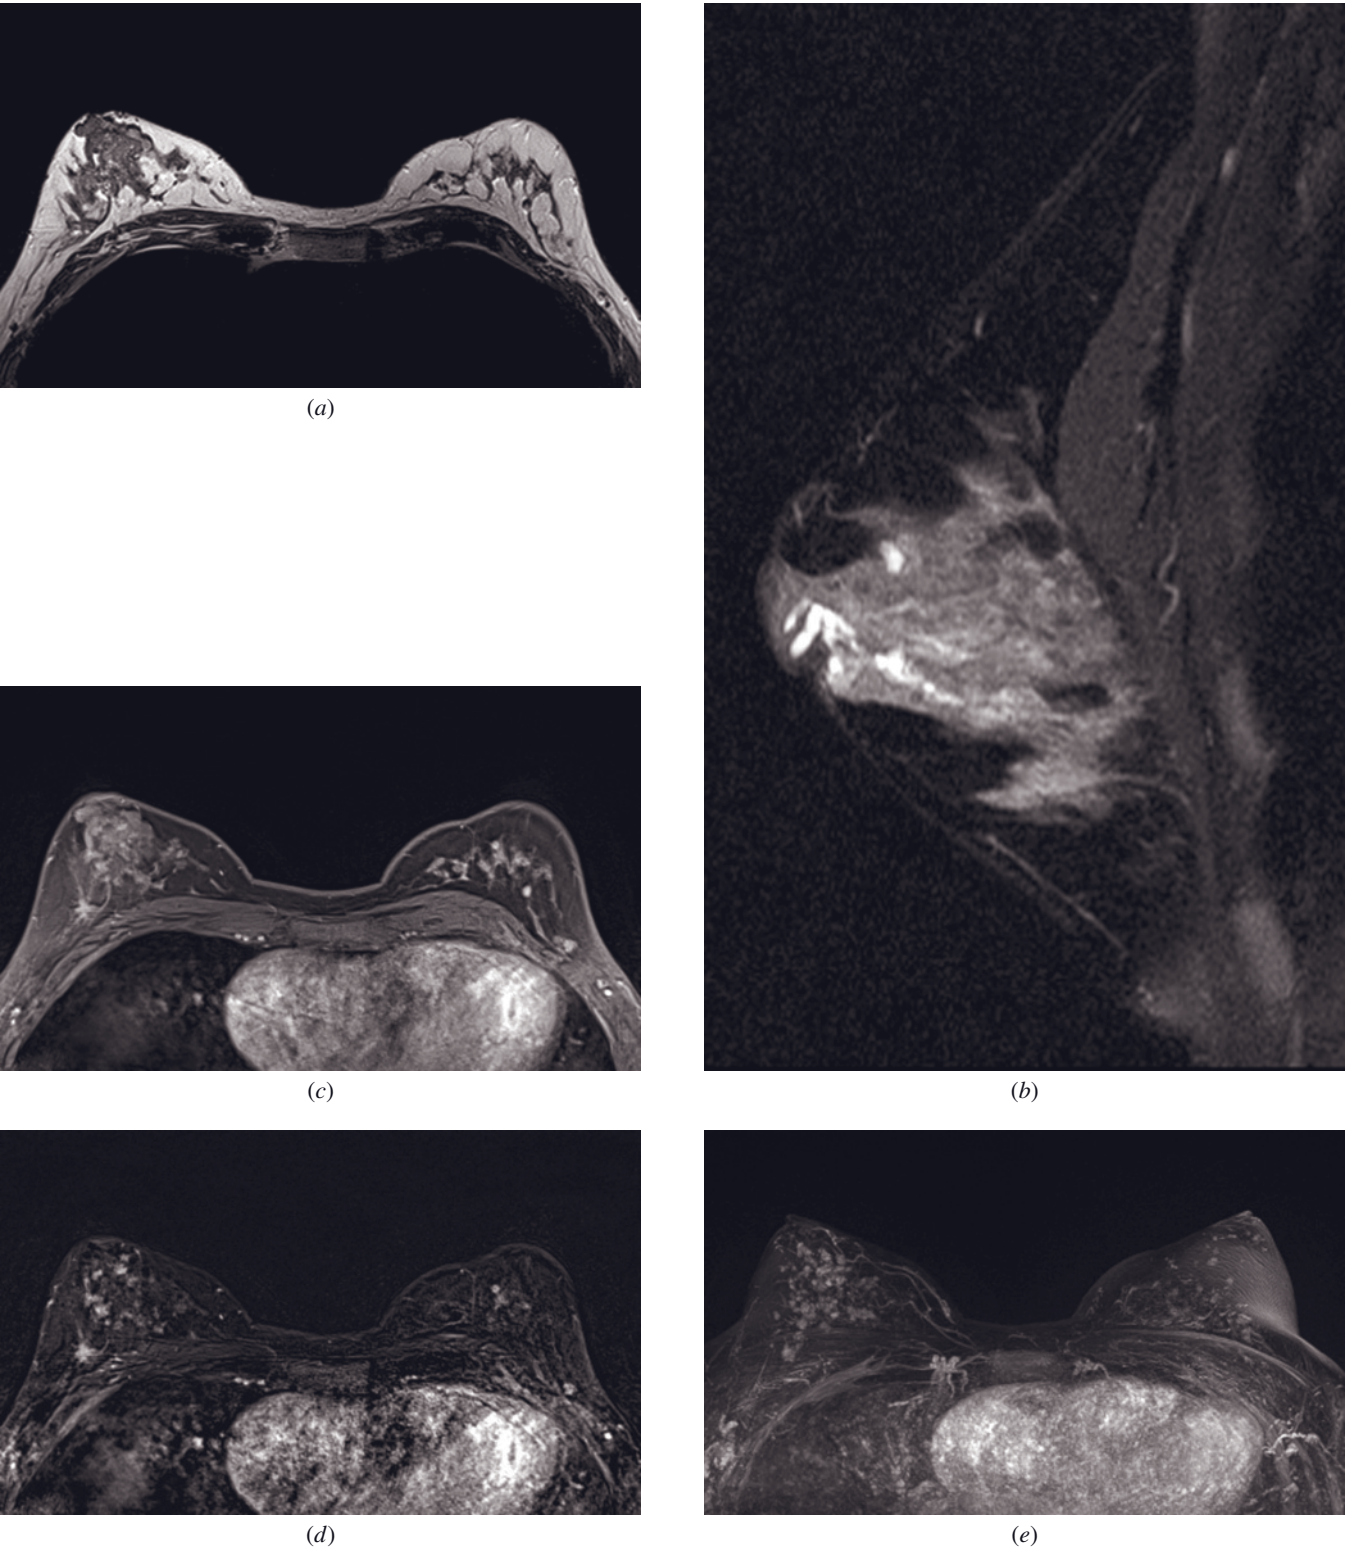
Multiple papillomatosis. T2-weighted (a) and sagittal fat-saturated T2-weighted (b) images show dilated ducts in the right breast. Axial postcontrast GRE (c), subtracted (d), and MIP (e) images reveal multiple enhancing, irregularly shaped lesions in both breasts, showing washout kinetics (f), thus indicating BI-RADS 4 lesions. US-guided core needle biopsy (CNB) of both breasts verified multiple papillomatosis.
